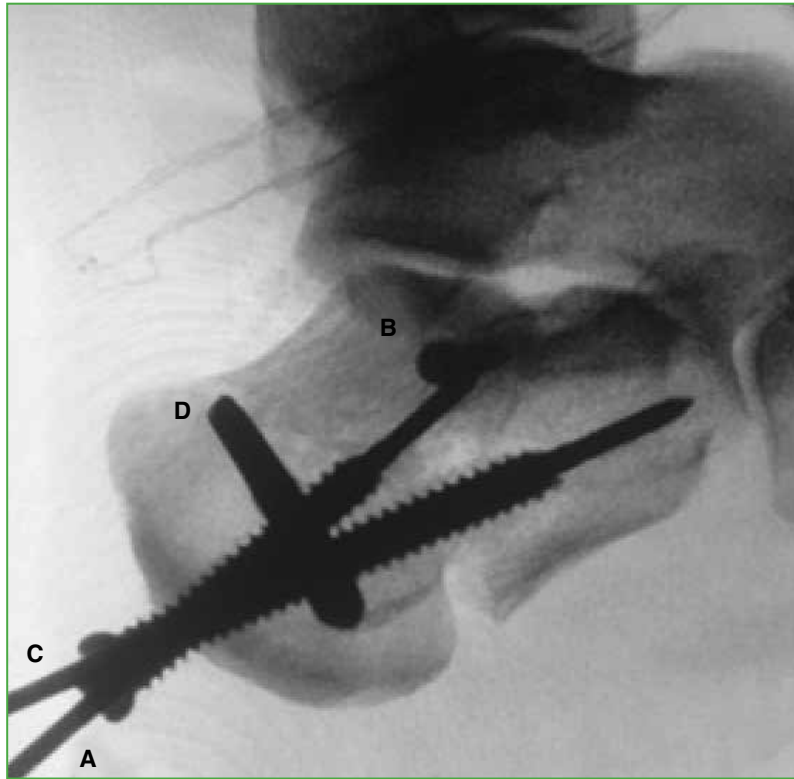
Intraoperative lateral radiographic view of the calcaneus. A. Guide pin parallel to the medial cortex, directed toward the sustentaculum tali, with its corresponding 6.5/7 mm cannulated screw. B. 3.5/4 mm cannulated screw used for osteosynthesis of the posterolateral articular facet of the calcaneus. C. Guide pin and corresponding 6.5/7 mm cannulated screw from the greater tuberosity to the lesser tuberosity. D. Transfixing Schanz nail placed parallel to the plantar cortex.
